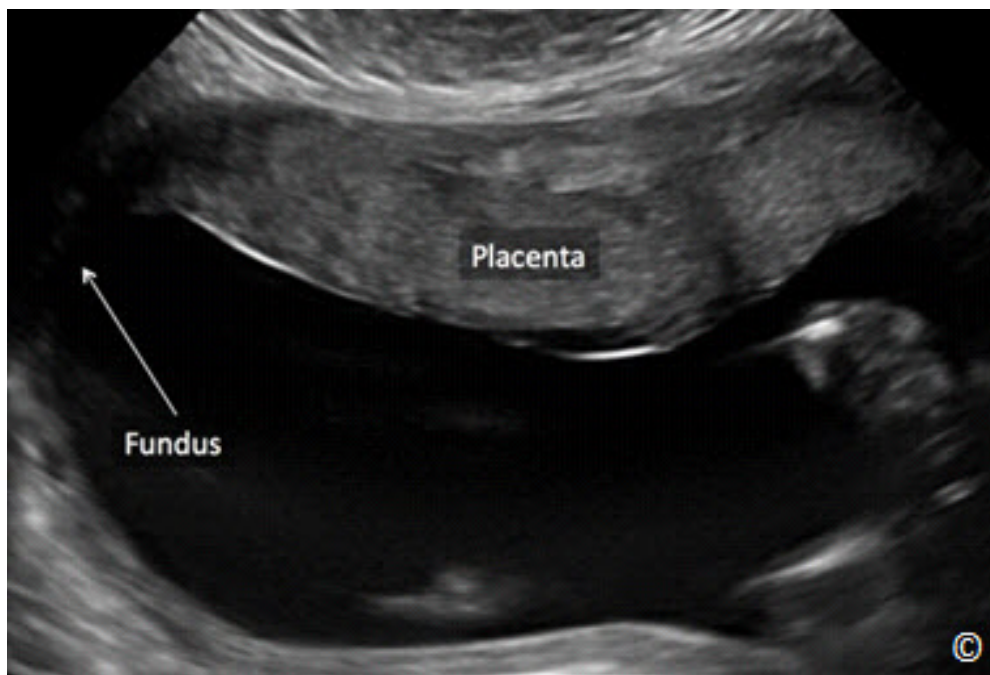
Anterior placenta (labeled) shown on ultrasound obtained from a sagittal view of the uterus. The uterine fundus is labeled. See text for details.
